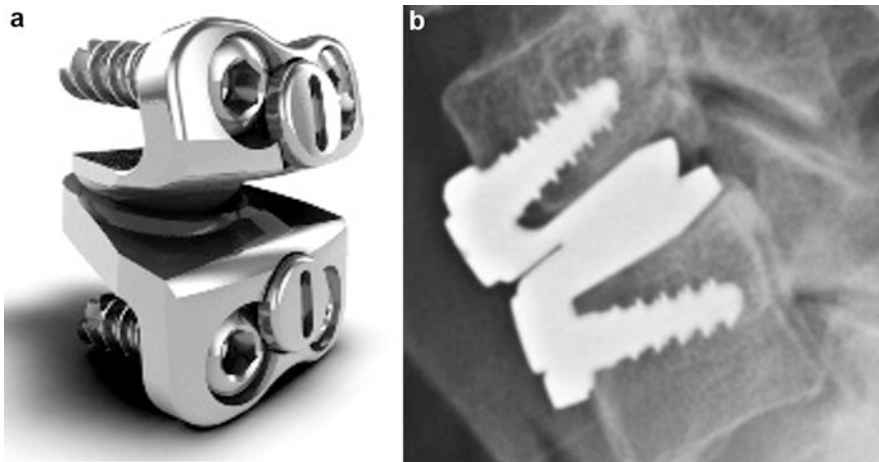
Prestige ST cervical disc: (a) device; (b) lateral X-ray after implantation
